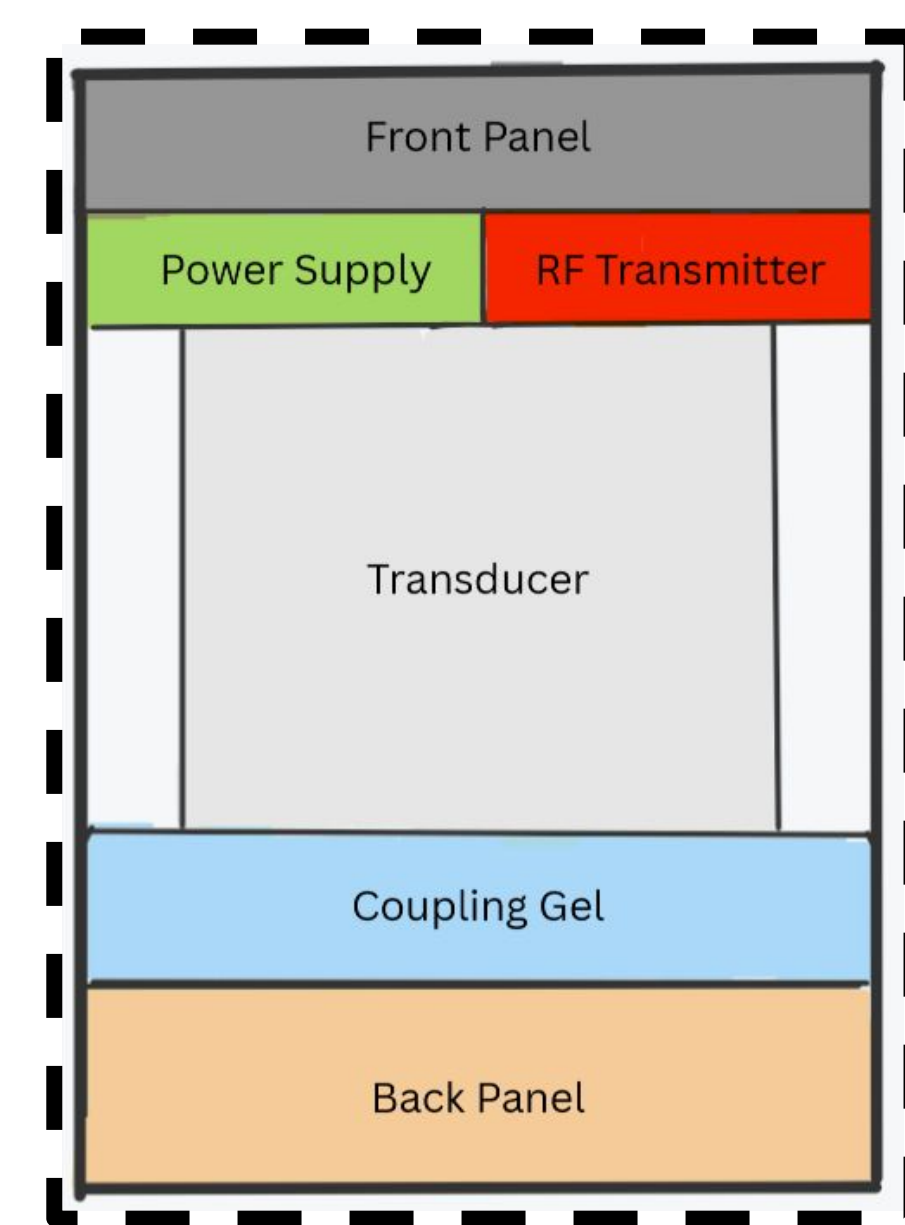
Assembly of transducer array for producing and receiving ultrasound waves
